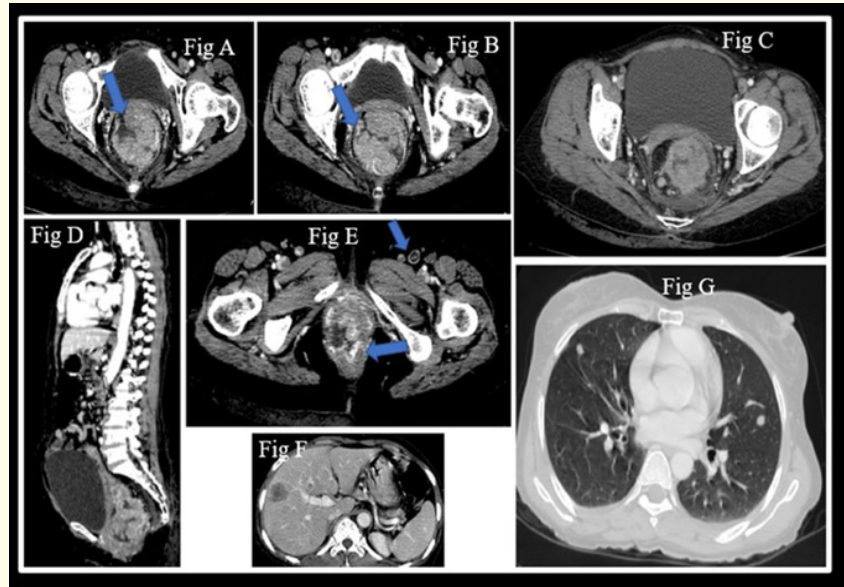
CT images of HPE proven Tubulovillous adenoma- high grade. A and B: Show an endophytic polypoid lesion in the rectum with the characteristic corrugated appearance in A and cerebriform brain appearance in B. C: lesion in the rectum and anal canal. D: Similar lesion in the anal canal. E: Prominent peri rectal vessels with enlarged inguinal nodes. F: Liver Metastases. G: Lung Metastases.
